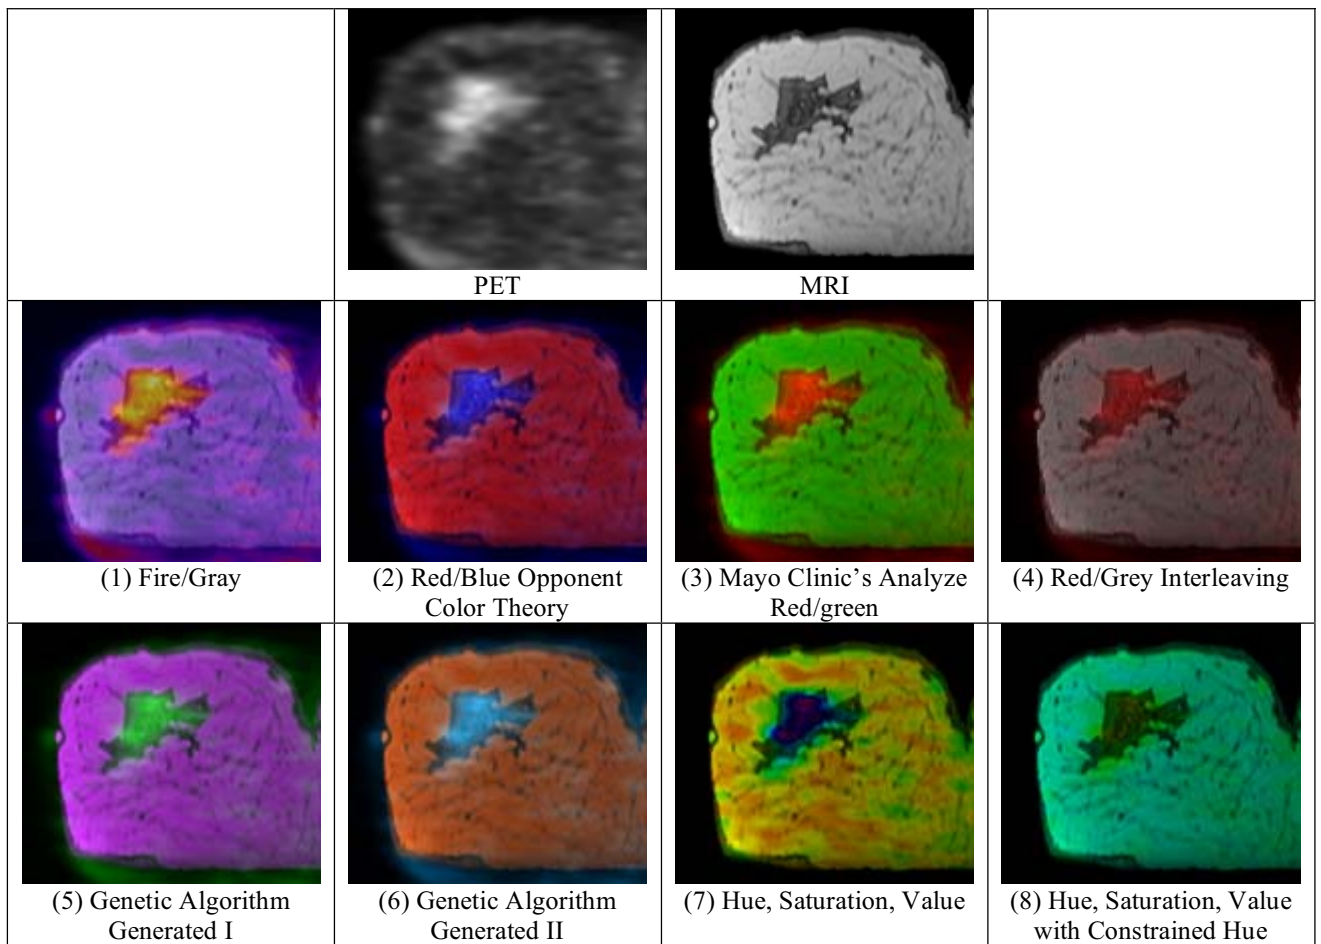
Fused images created using each technique. The PET and MRI source images used are shown in the top row.
